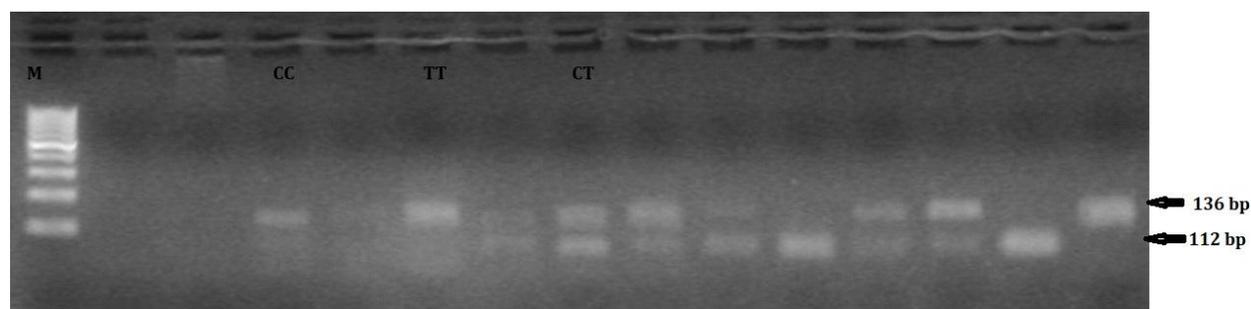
PCR-RFLP analysis of the TCF₇L₂ (rs7903146) locus revealed two bands of 112 bp and 24 bp in the TT homozygote genotype, one band of 136 bp in the CC homozygote, and three bands of 136 bp, 172 bp, and 24 bp in the CT heterozygote genotype. M = 100 bp ladder DNA marker.
